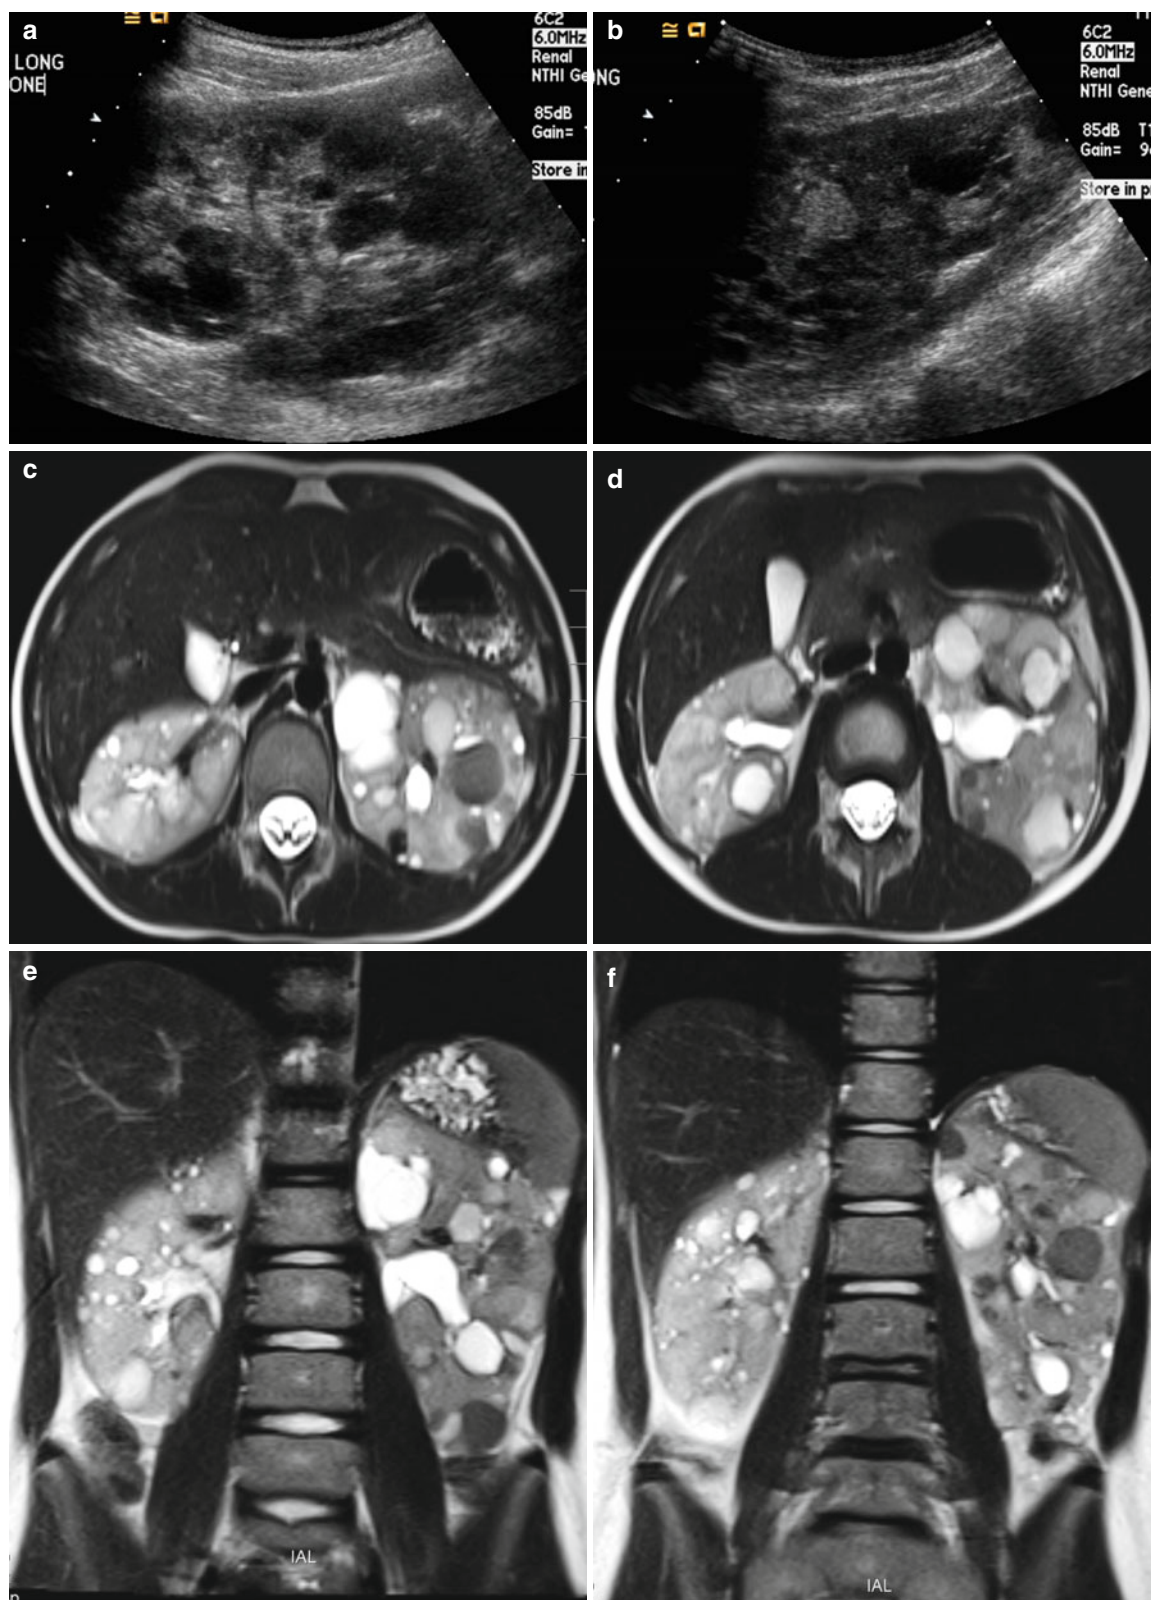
Autosomal dominant polycystic kidney disease in a 6-year-old girl. (a and b) Longitudinal US of the left kidney demonstrates multiple, variable-sized hypoechoic cysts. Note multiple echogenic round cysts, which represent hemorrhagic cysts. (c and d) T2-weighted axial MR images demonstrate variable-sized cysts
